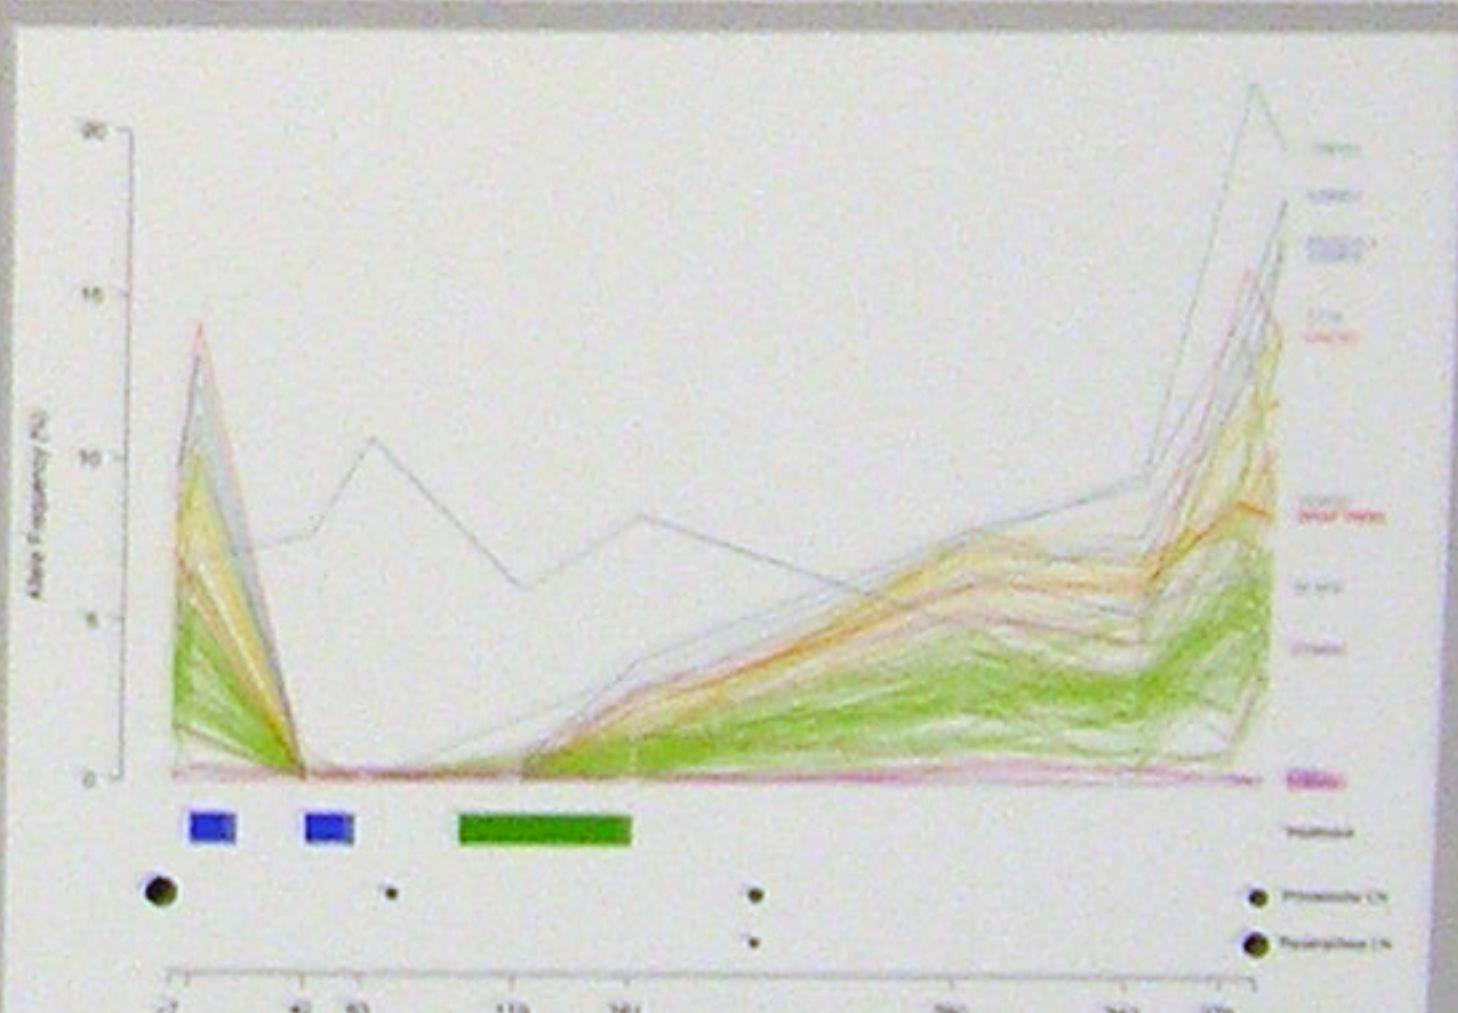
Allele frequency trajectory of 100 somatic mutations through treatment course. Variants tracked by amplicon-based sequencing of cfDNA samples on PGM (Life Tech). Loci assigned one of 8 colours based on hierarchical clustering (Euclidean distance). Treatment cycles of vemurafenib (blue) and ipilimumab (green) indicated as rectangles. Tumour diameter of prevascular lymph node (top), paratracheal lymph node (bottom) obtained using CT imaging.
